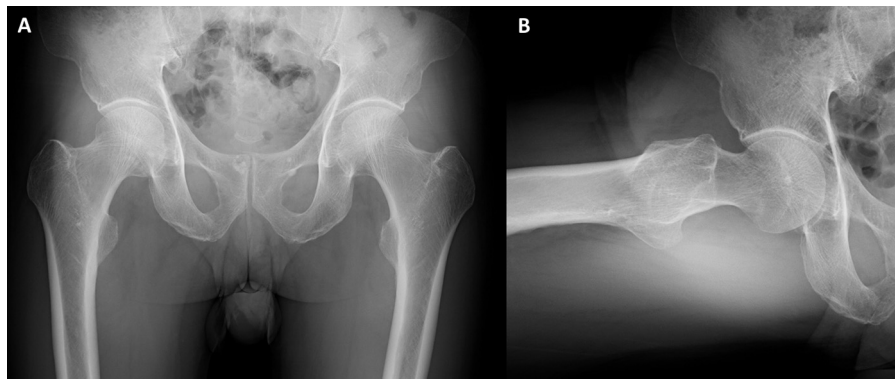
Radiographs obtained 2 weeks after the onset of right hip pain. There were no significant findings on either the (A) anteroposterior view or the (B) frog lateral view.
